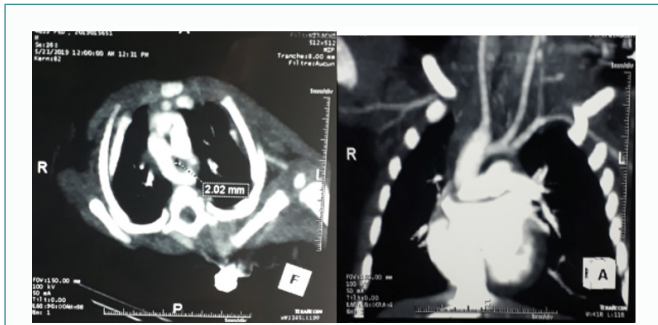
Chest CT scan showing a double aortic arch with right arch dominance.
